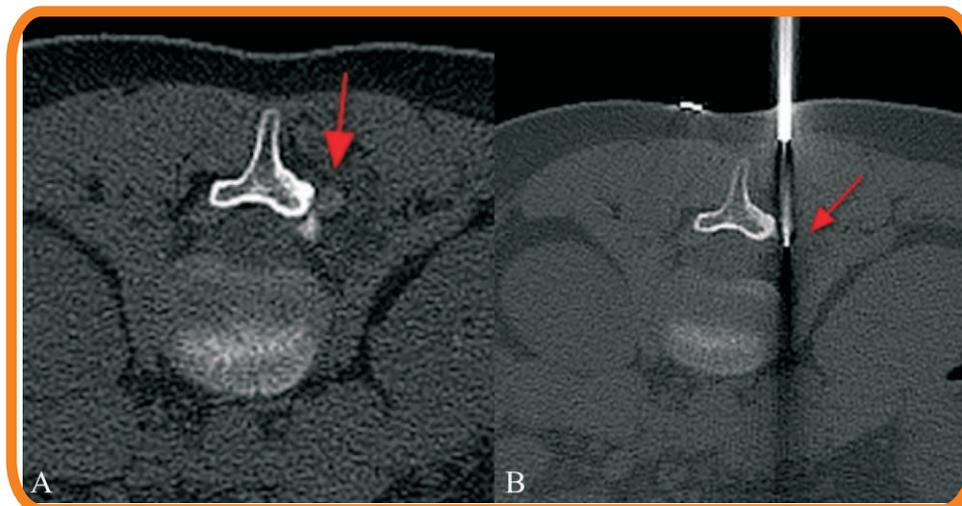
(A,B): Prone axial CT scan (A) shows an osteoid osteoma (arrow) adjacent to the L2 pedicle on the undersurface of the transverse process. This is far away from the thecal sac and nerve root. The prone axial CT scan (B) shows the position of the electrode (arrow) and the lesion was safely and easily ablated with complete relief of pain.
